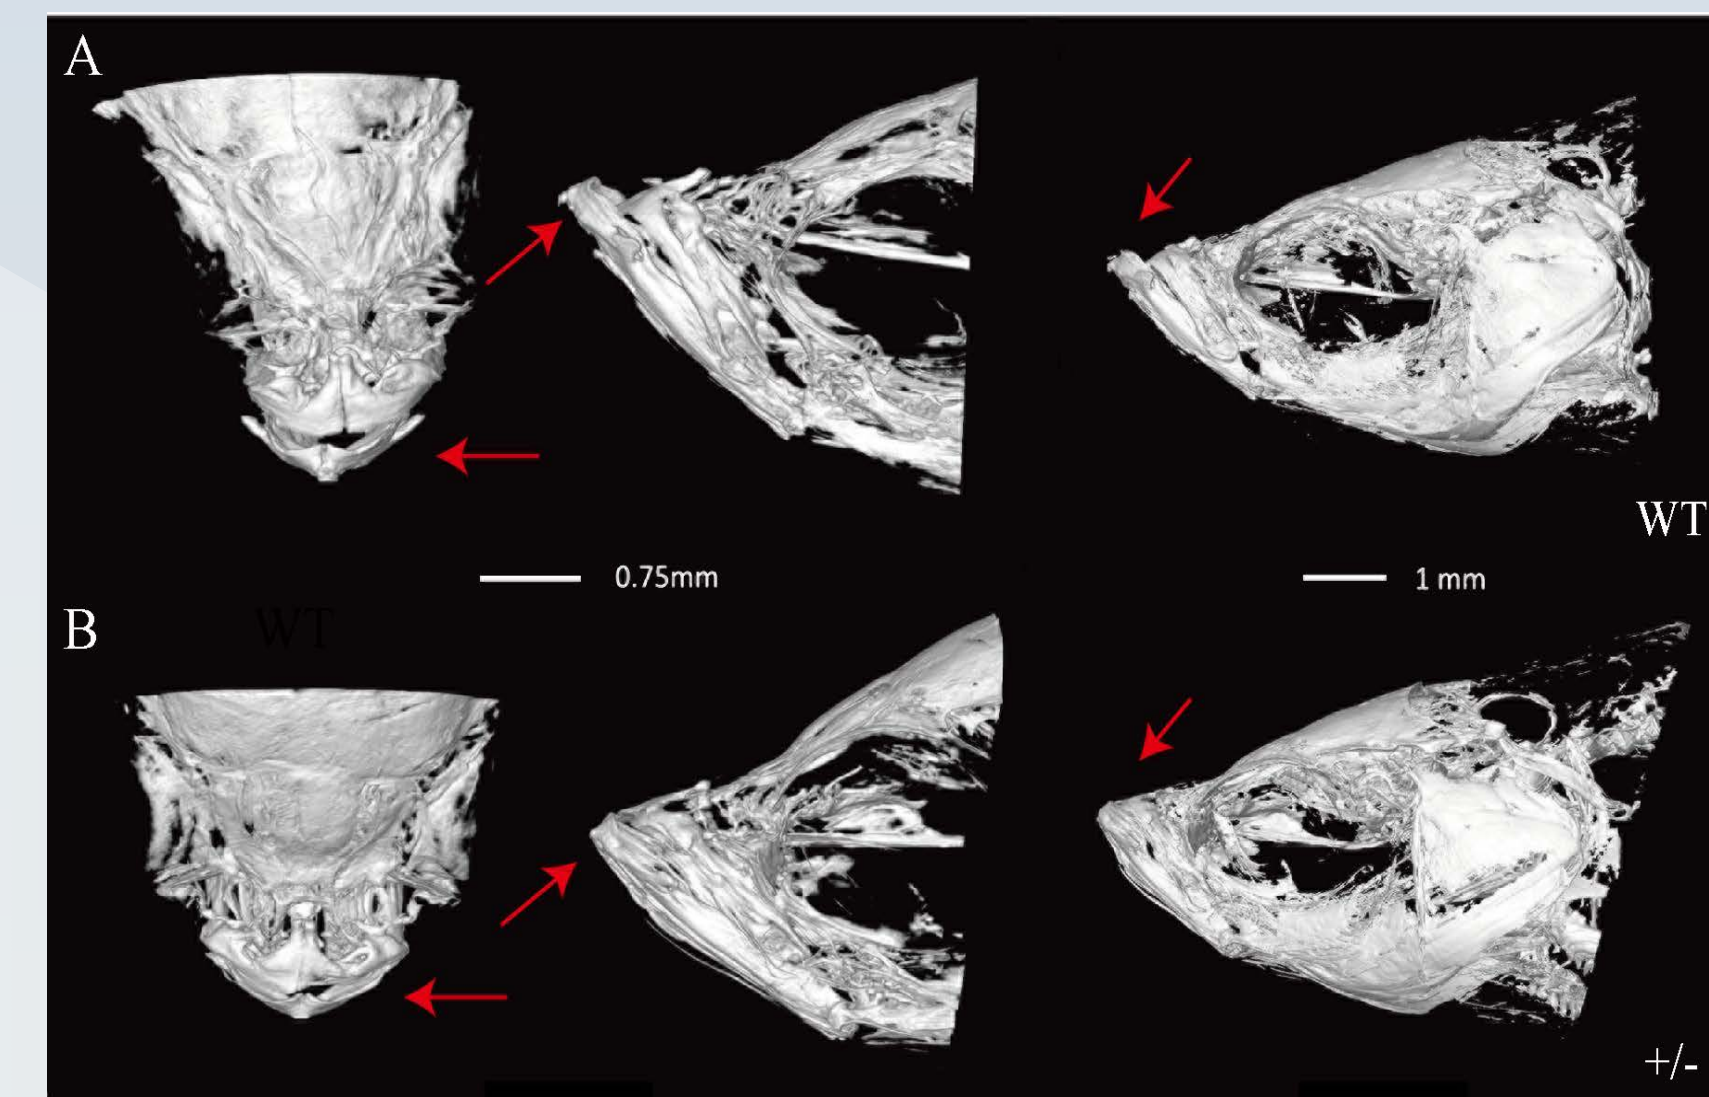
A) Mandible bone of wild-type adults (WT) scanned by synchrotron radiation X-ray microtomography. B) The heterozygous F2 generation (+/-) exhibited a shortened mandibular bone (arrows).
